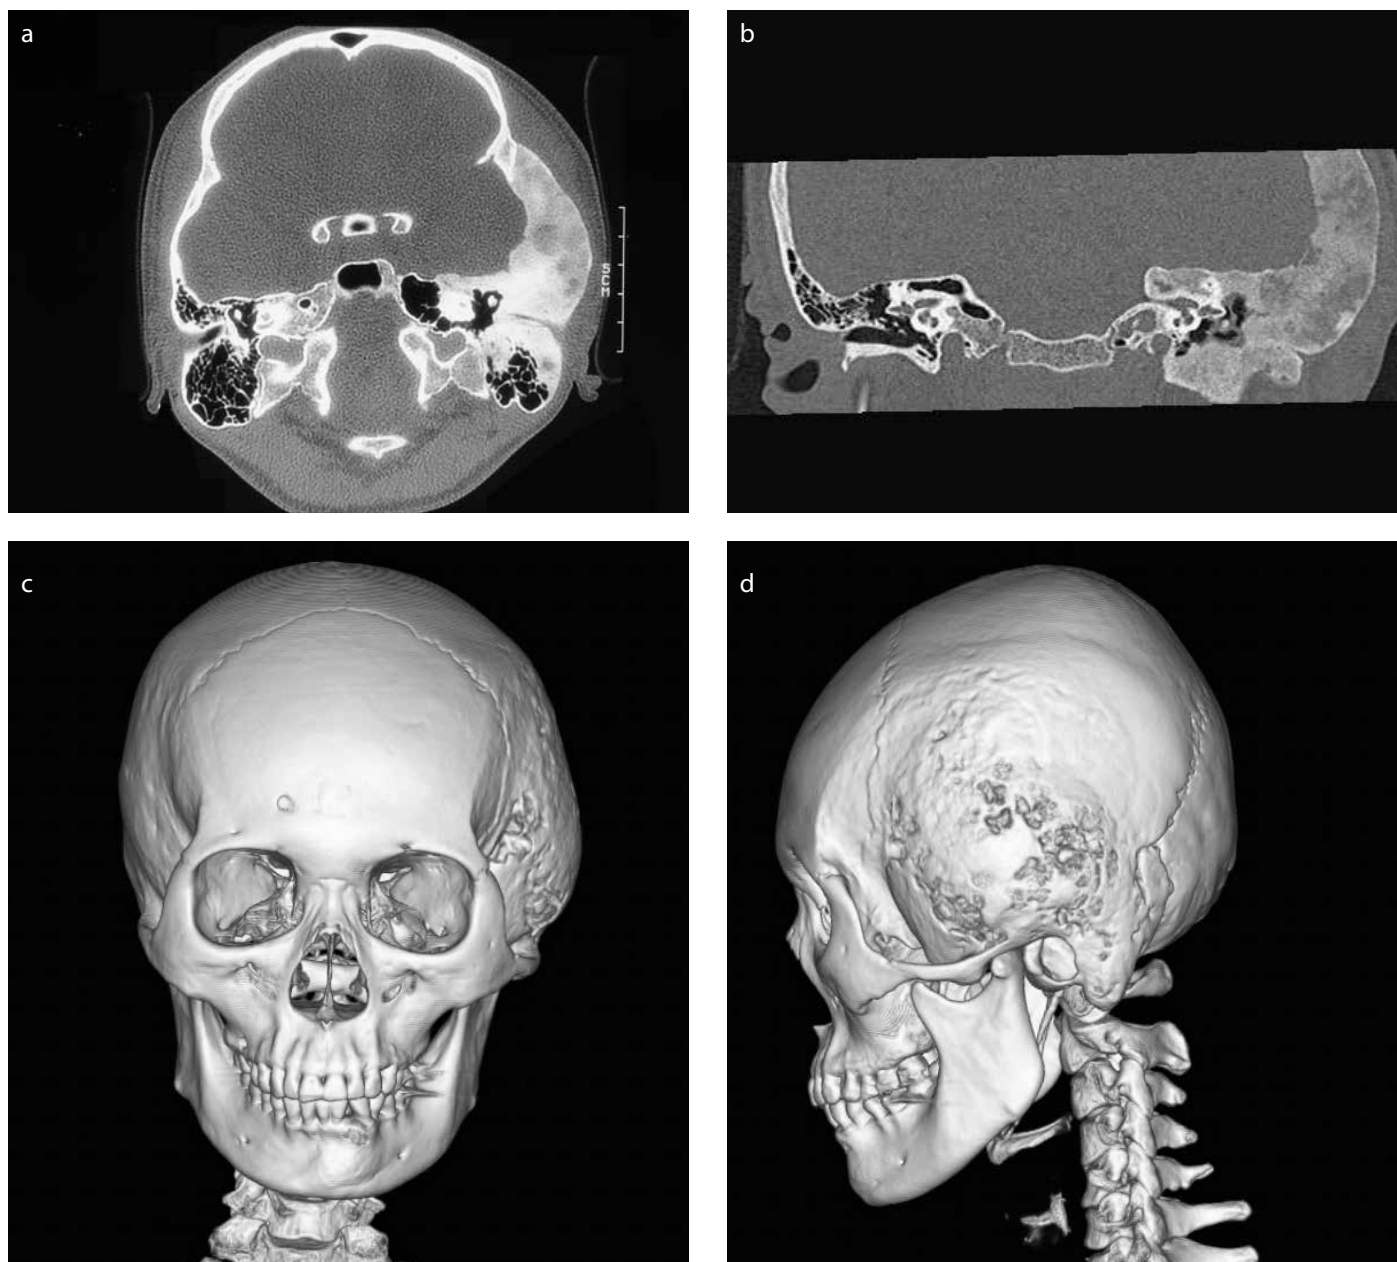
a-d. Repeated non-contrast temporal HRCT series: Axial (a) and coronal (b) views showed the progression of left temporal fibrous dysplasia with soft tissue opacities in the left middle ear. Three-dimensional reconstructed images showed anterior (c) and lateral (d) appearances of the expansile left temporal bone
